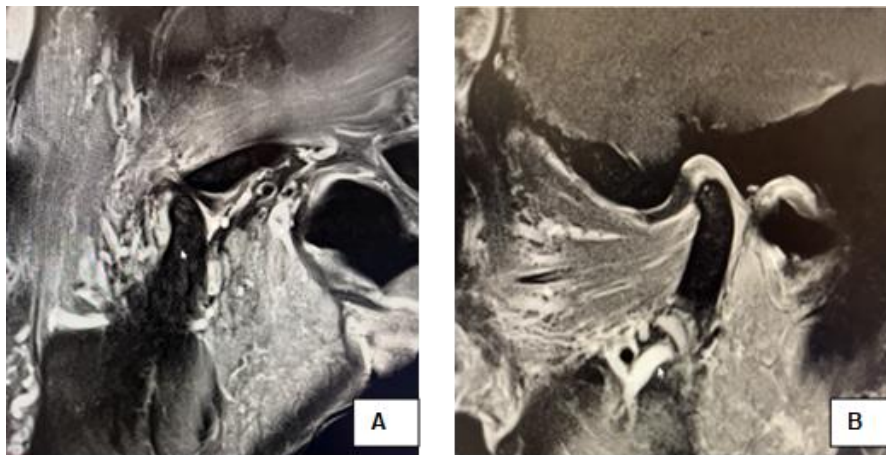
&B_showing a postoperative MRI for the patient with disc recapturing in open mouth position.
